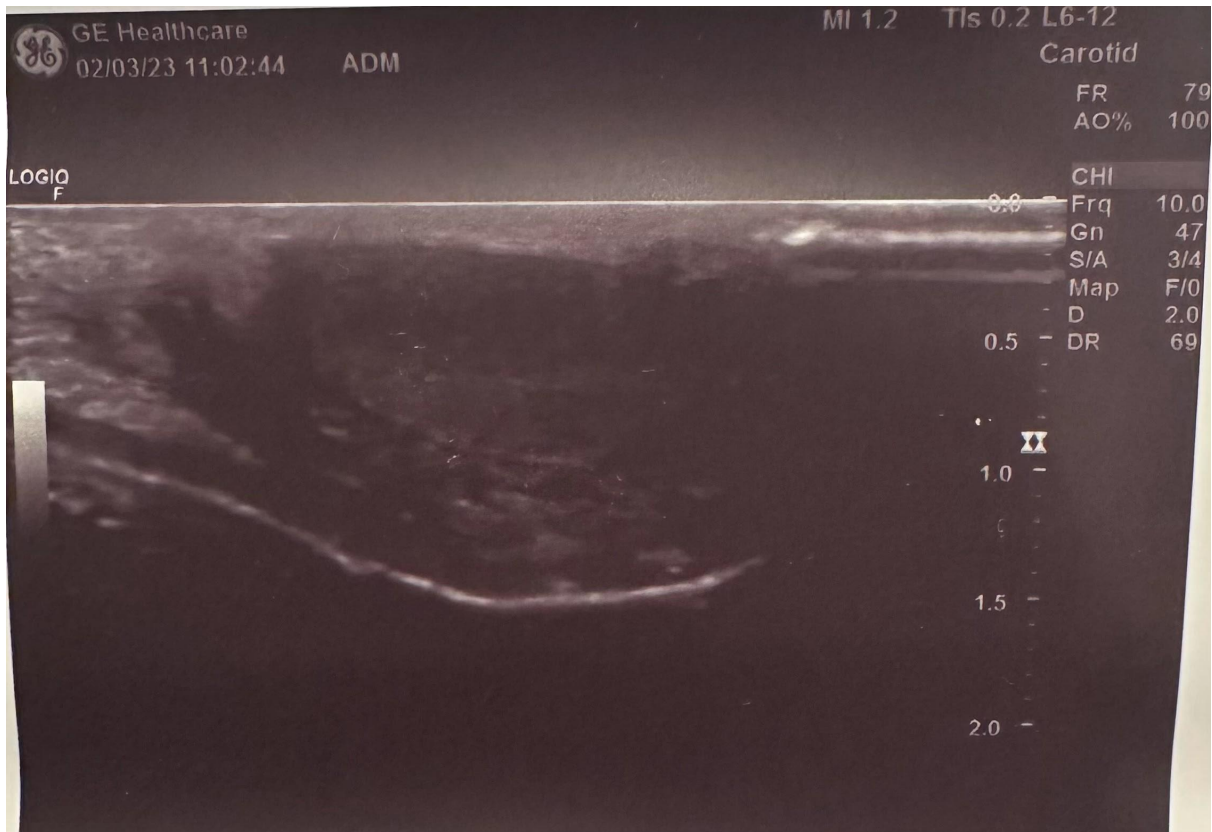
Longitudinal ultrasound scan of the scrotal sac showing a hypoechoic testis with a hyperechoic intestinal loop located above it.
